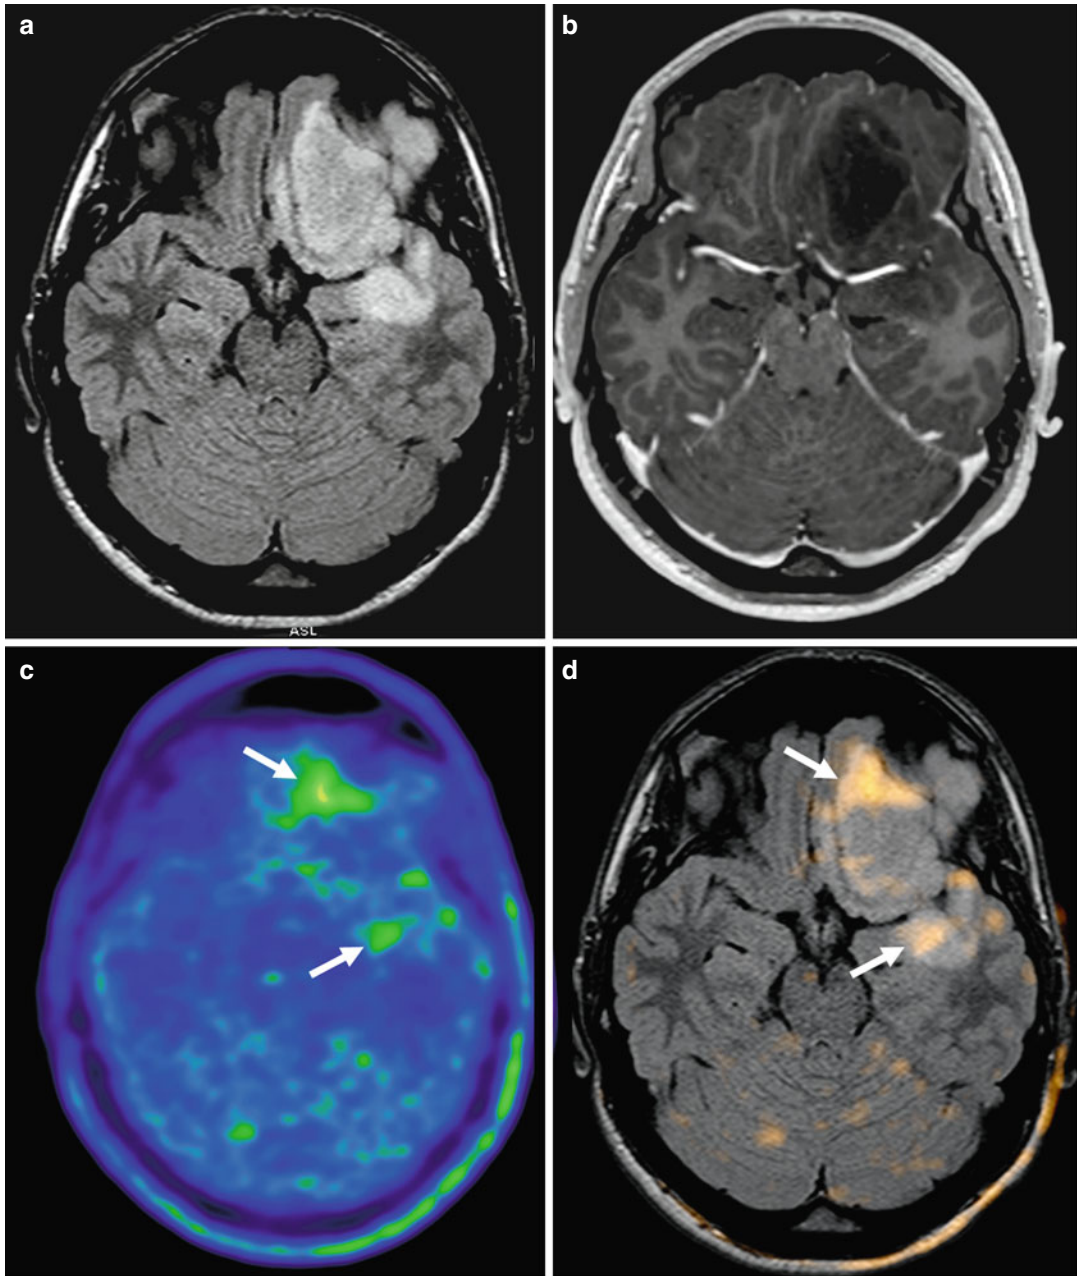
Diffuse astrocytoma (WHO grade II) in a 17-year-old-boy. (a) Axial FLAIR image; (b) Gd-enhanced axial T1-weighted image; (c) axial 18 F-DOPA PET/CT image; (d) fused PET/MRI image. Left temporal-frontal
